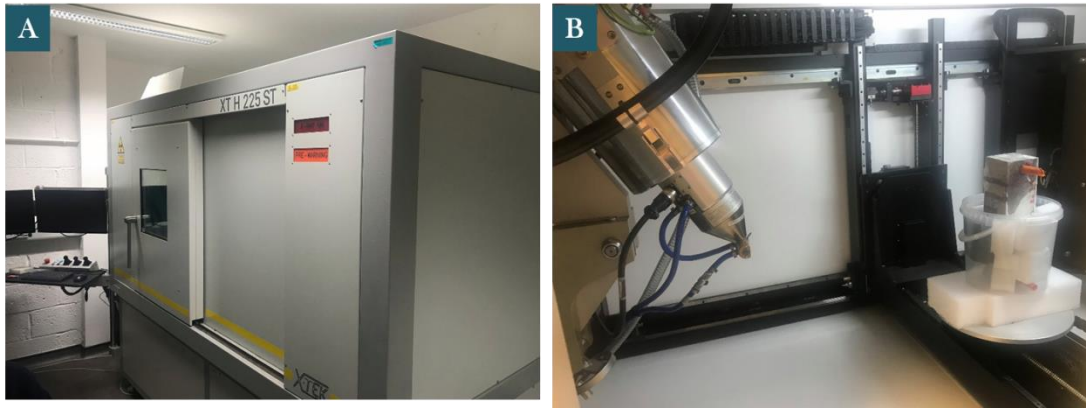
Nikon® X-Tek H 225 ST CT-scanner for computational tomography analysis, (A)CT-scanner and (B) X-ray source and sample placement
